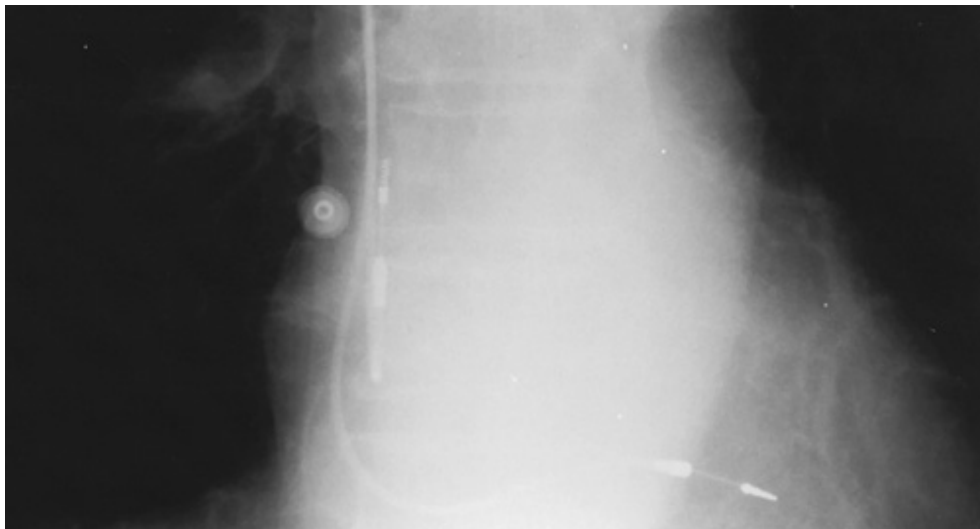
Chest x-ray from a patient with a bipolar dual-chamber pacing system. The atrial lead is attached to the right atrial appendage by active fixation (screw-in lead), and the screw is visible on the chest x-ray. The ventricular lead is attached to the ventricle by passive fixation.
